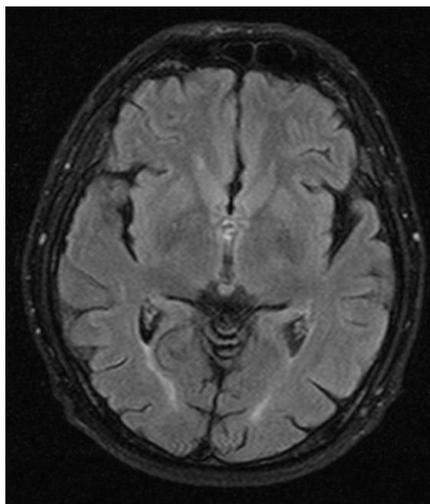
The image in FLAIR mode
